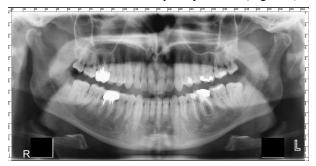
Panoramic radiological investigation showing the presence of one supplemental maxillary lateral incisor normally aligned in the right part of the jaw. L: Left; R: Right.
